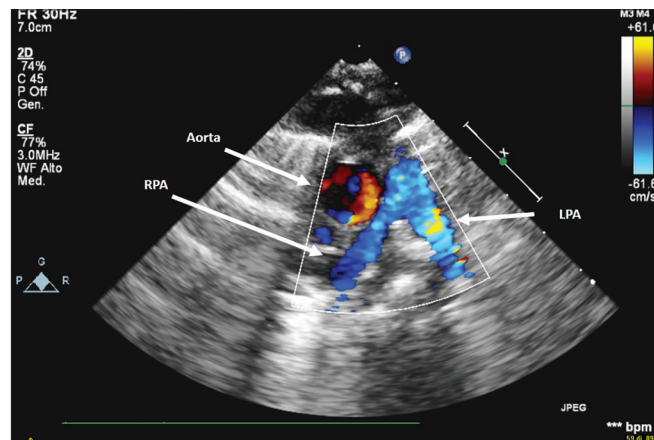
Seven-year follow-up – echo short-axis parasternal view. Aorta, RPA: Right pulmonary artery, LPA: Left pulmonary artery
